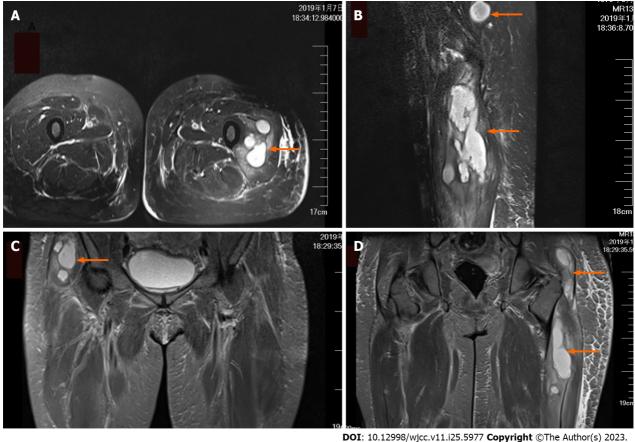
Abscess (arrow) in the gluteal and quadriceps muscles as visualized by T2-weighted magnetic resonance imaging. A: Axillary view; B: Sagittal view; C and D: Coronal view.
